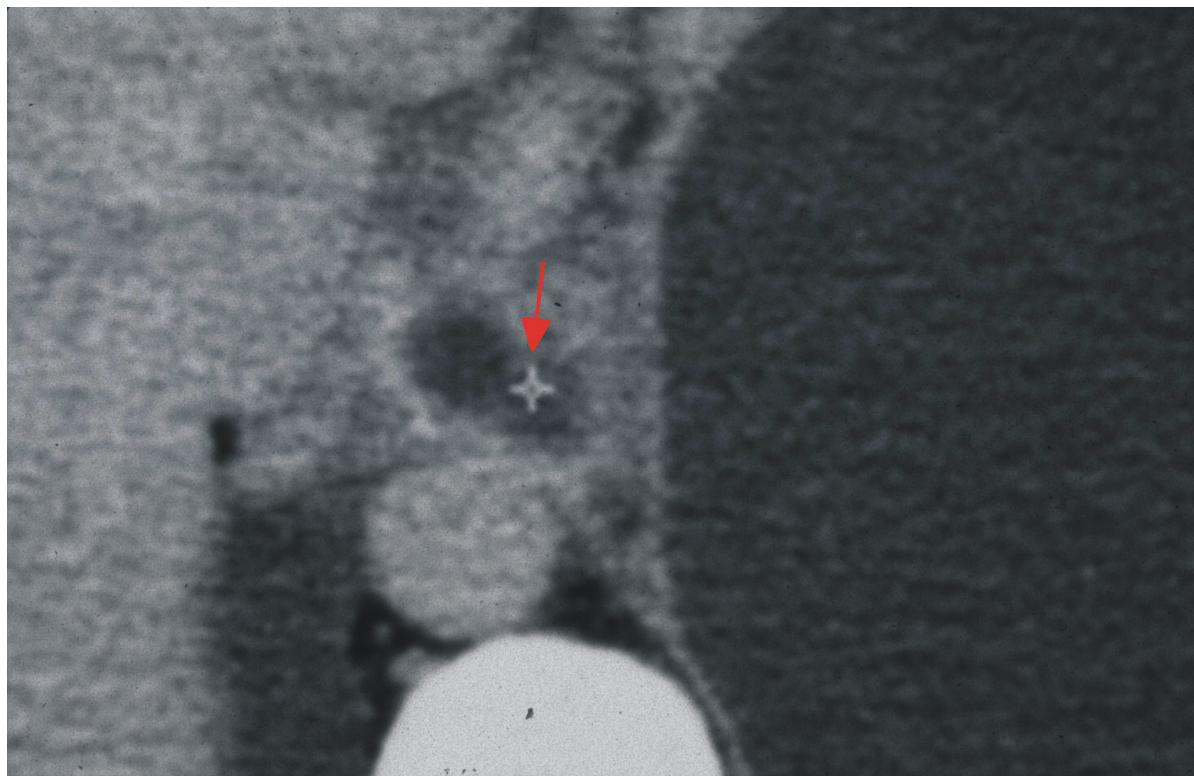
CT -- on the 5 cm more cranial scan fistula is situated between aortic and oesophageal hiatus.
